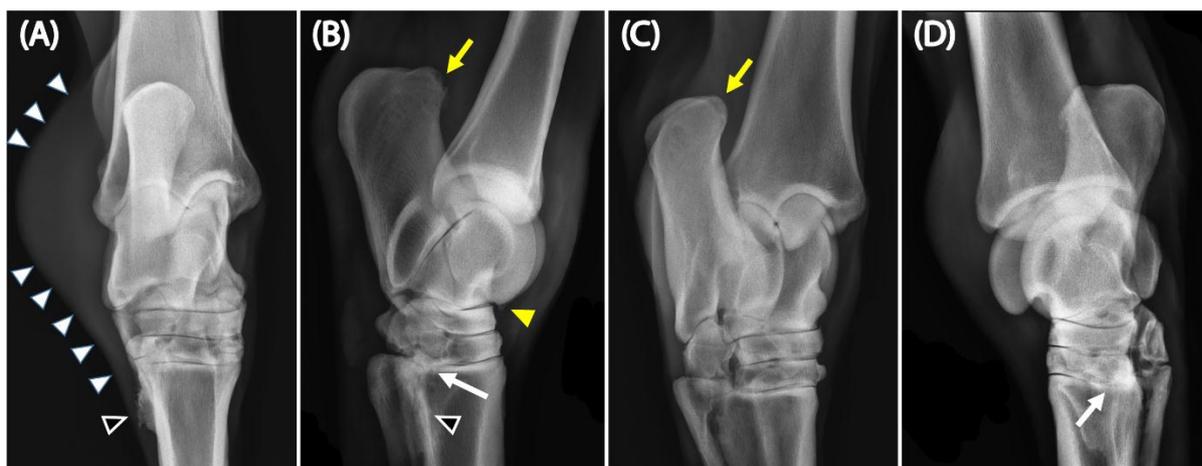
The radiographic images demonstrated multiple defects, including 1) soft tissue protuberance at the lateral aspect of the joint (sequential white triangles) (A) and a enthesophyte formation at the lateral aspect of the proximolateral angle of the third metatarsal bone (black-white triangles) (A and B), 2) a bone spur at the trochlea ridge of the talus (yellow triangle) (B), 3) a sclerotic lesion of the osseous margin at the tarsometatarsal joint (white arrows) (B and D), 4) various radiolucent areas indicating subchondral bone lysis on the ventral surface of the fourth tarsal bone (B), and 5) a radiolucent area at the dorsal aspect of tuber calcanei (yellow arrow) (B and C).
